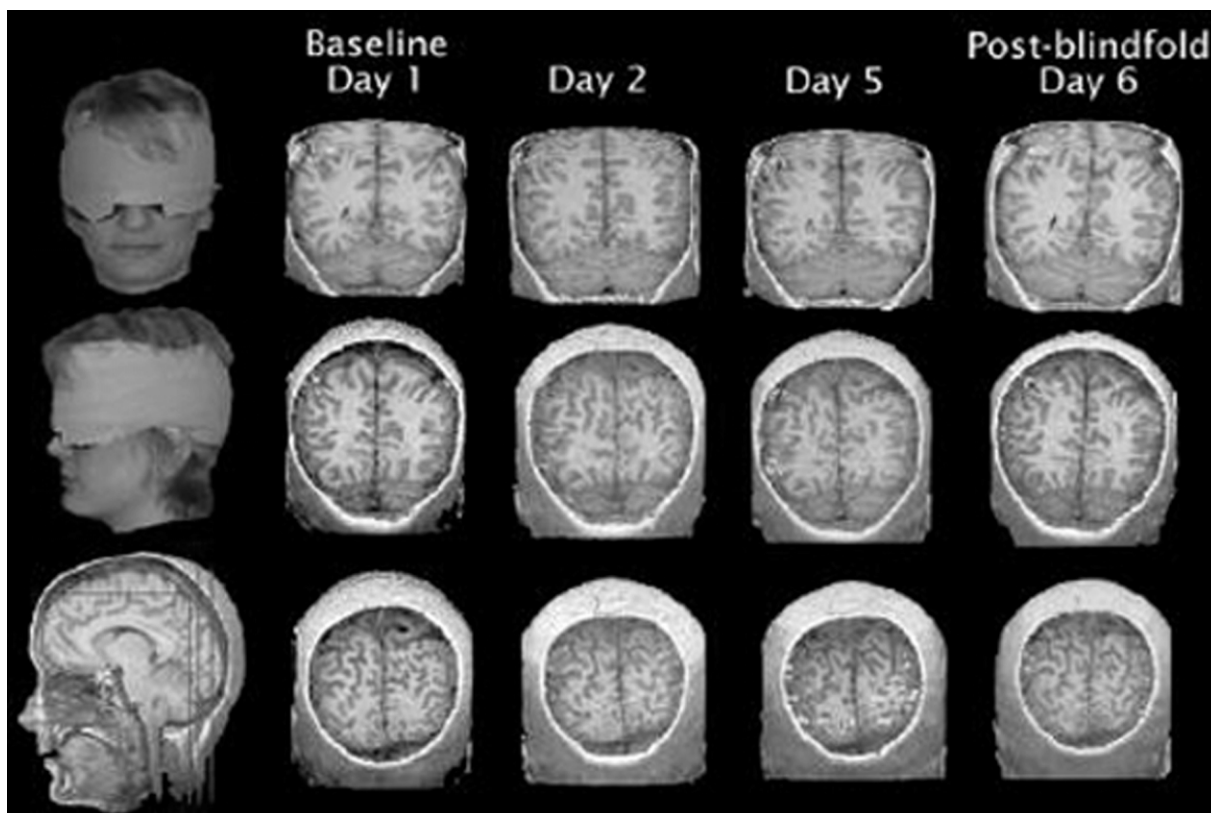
Representative example of the changes in BOLD activation on functional brain MRI over the course of 5 days of complete visual deafferentation through blindfolding. Note the increasing activation of occipital cortex, including striate cortex by the fifth day of blindfolding and the dramatic return to baseline following removal of the blindfold for a single day (despite testing with the blindfold on).
